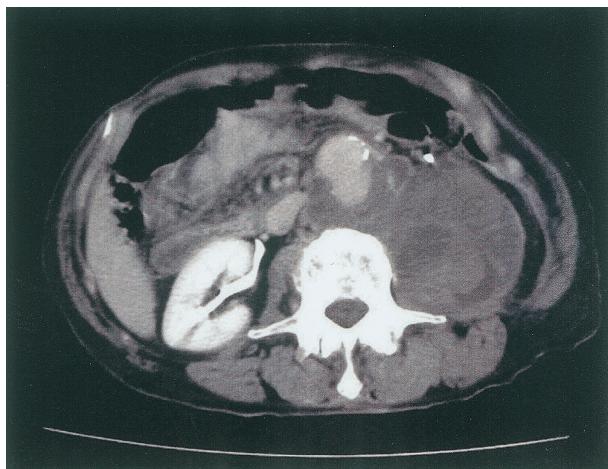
Abdominal CT in another hospital admission showing a rupture of an abdominal aortic aneurysm.
